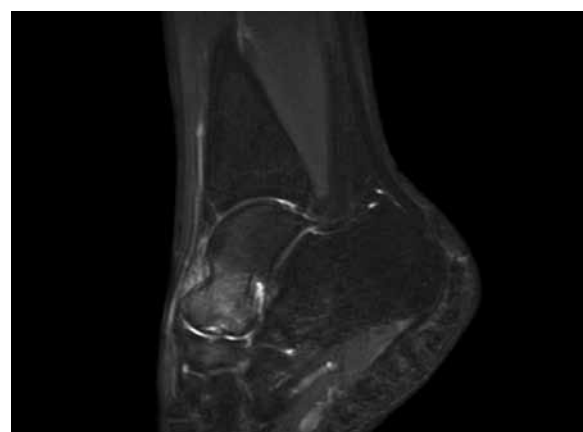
Preoperative sagittal T2-weighted image of the right ankle with osteochondral lesion of talar head
